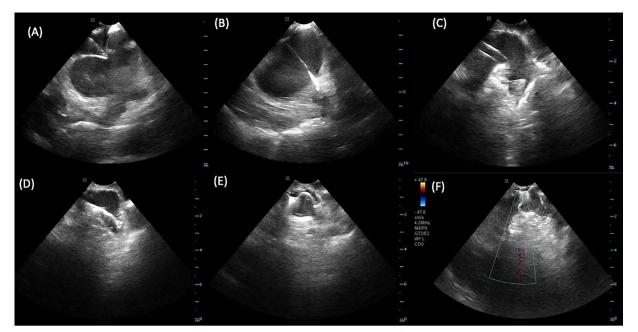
Step-by-step percutaneous left atrial appendage (LAA) closure with Watchman FLX device under intracardiac echocardiography (ICE). (A) Trans-septal puncture under ICE. (B) Guidewire positioning on the left superior pulmonary vein. (C) Delivery sheath is advanced into the left atrium. (D) Delivery sheath is placed into the proximal part of LAA. ICE probe is now into the left atrium to visualize better the LAA. (E) LAA occluder deploy. (F) The device has been opened and is now prepared for evaluation via tug test to confirm stability and color Doppler to exclude leaks. Subsequently, it will be released. [Color figure can be viewed at wileyonlinelibrary.com]
